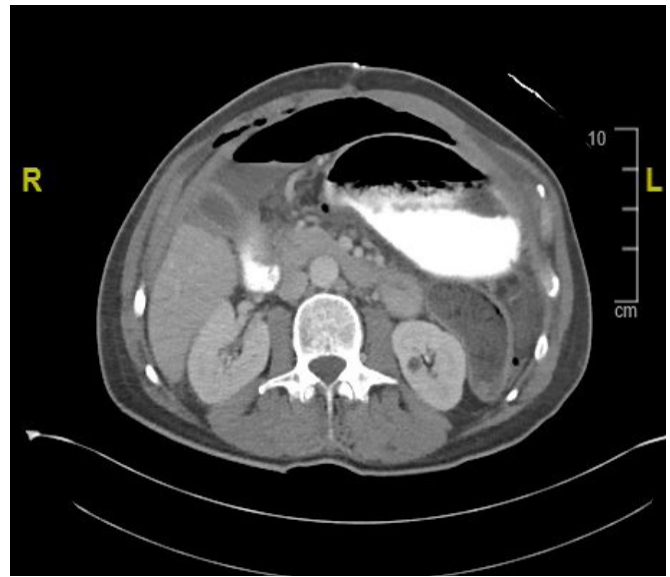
CT showing colonic perforation and ascites
